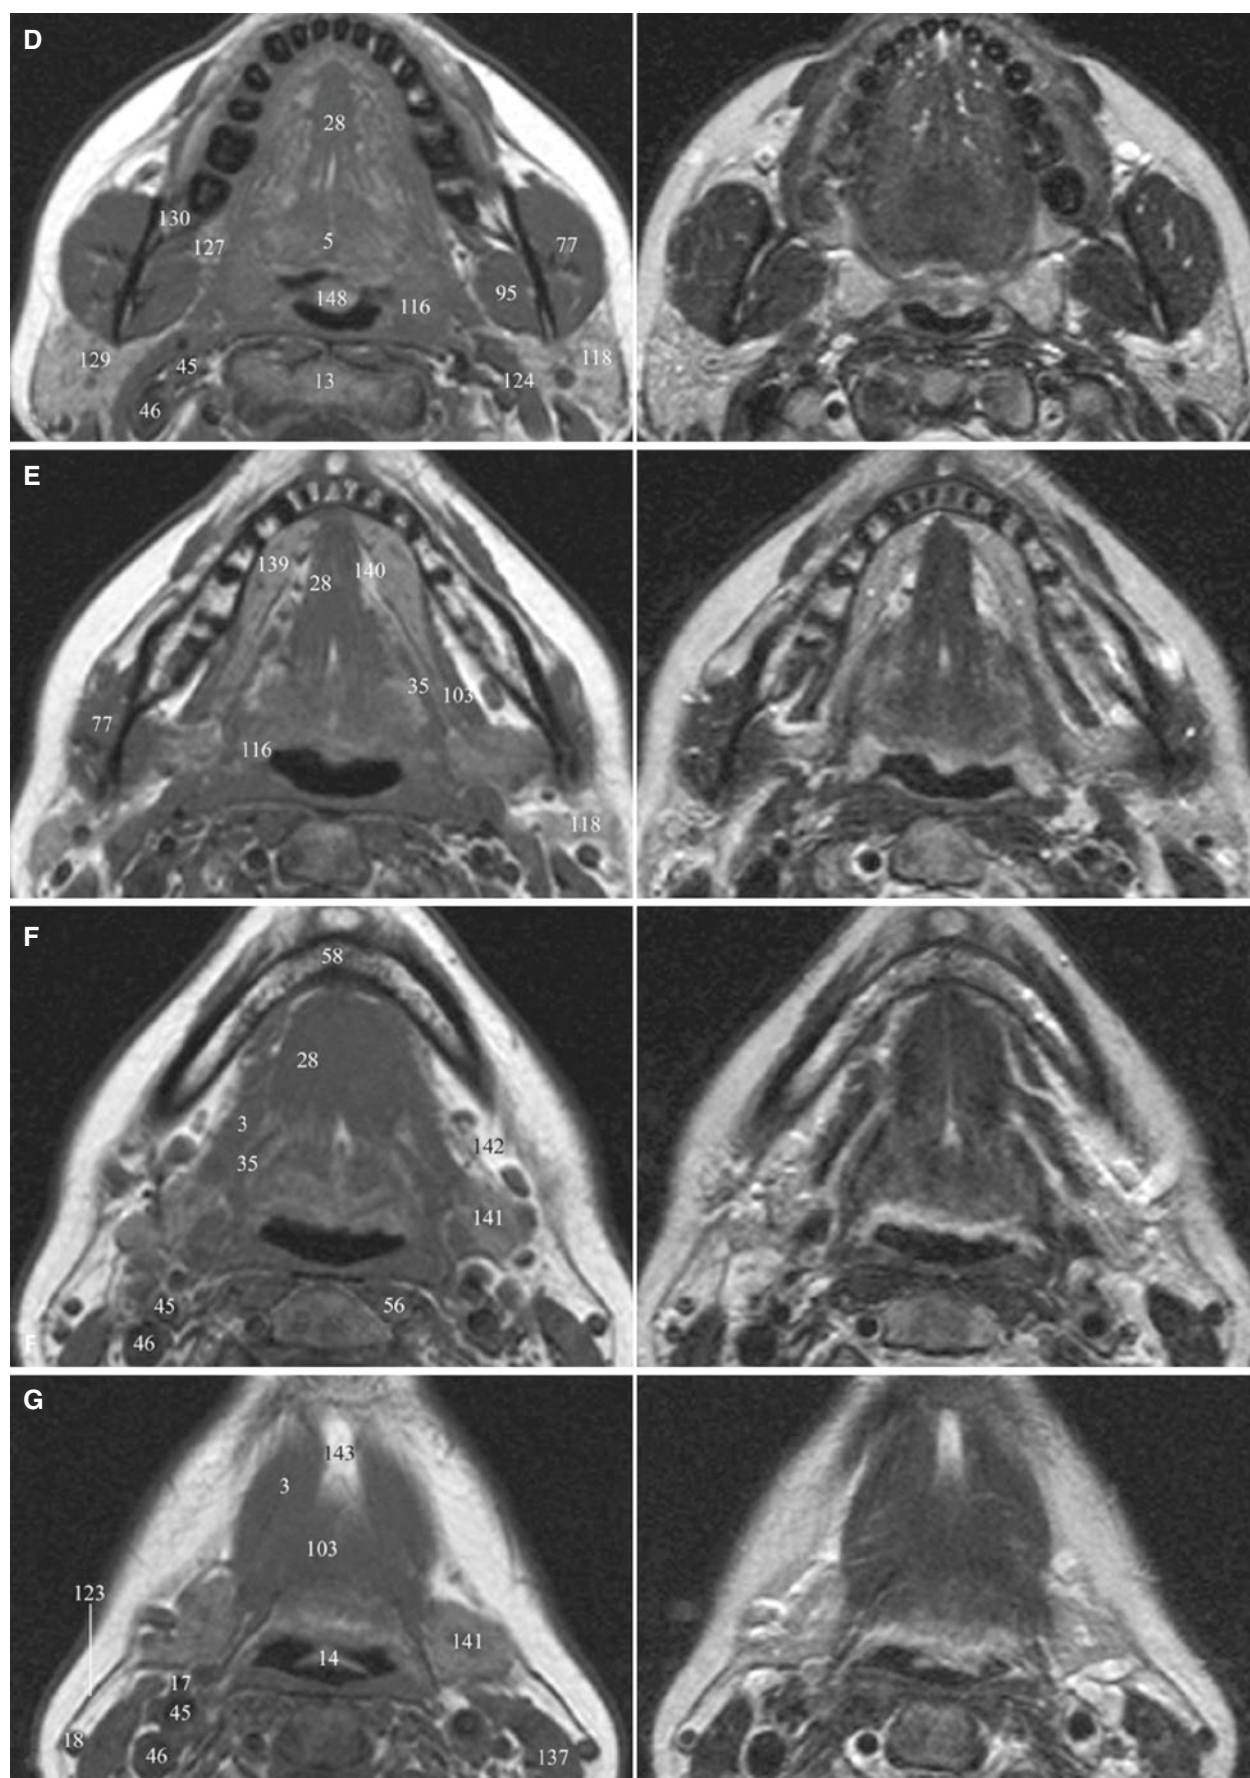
Normal anatomy of the face; axial T1- and T2-weighted MR images from superior (A) to inferior (G)
